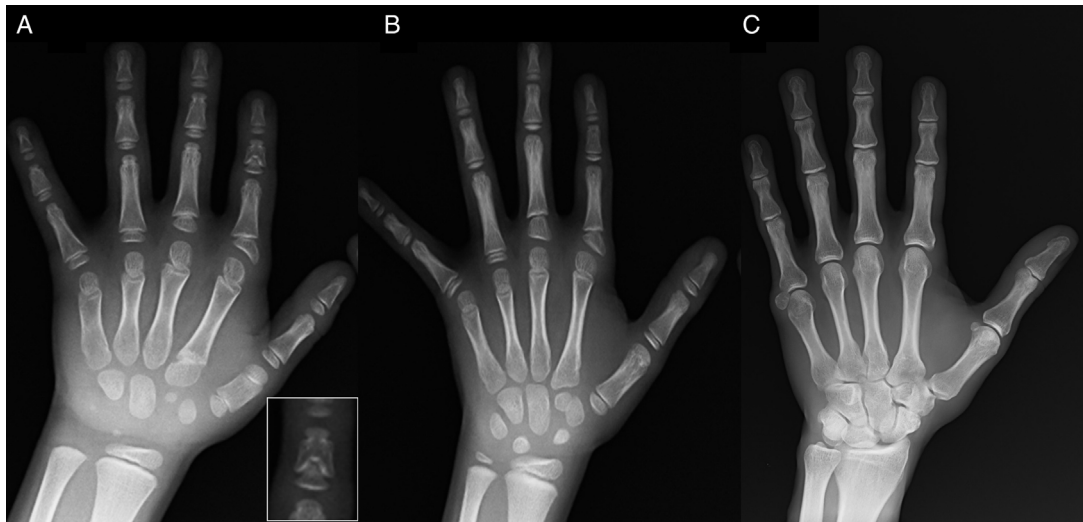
(A) Radiograph of the left hand of the proband (chronological age, 7 years; bone age, 5 years), with shortening of an anomalous first metacarpal (double proximal and distal epiphyseal plates) and the middle phalanges of the second, third and fifth fingers. The second finger exhibits ulnar deviation, and the fourth finger is the least affected and longest in the left hand. The proximal epiphyses of the second and third finger are dysplastic, with a conspicuous angel-shaped middle phalanx in the second finger (inset in A). (B). Radiograph of the left hand of the proband's sister (aged 5½ years with no delay in bone age), with shortening of the middle phalanges of the second, third and fifth fingers and a normal fourth finger. In this case, the first metacarpal was normal. The most salient feature is the triangular shape of the proximal epiphysis of the second finger's proximal phalanx, similar to the brother's, and the trapezoidal shape of the phalanx in the middle finger. Like her brother, her second finger exhibits ulnar deviation. (C) Radiograph of the left hand of the father of the proband, which reveals only a bony remnant of a post-axial hexadactyly that was surgically corrected in childhood.
